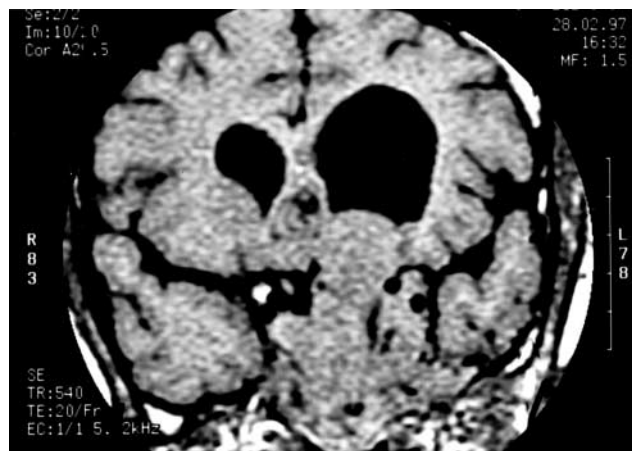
MRI coronal view of brain showing hydrocephalus and a large heterogeneously enhancing pituitary mass with suprasellar expansion and extension into sphenoid sinus
